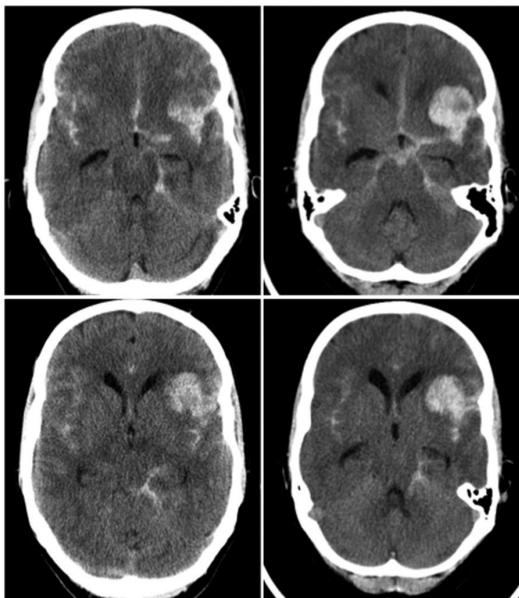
A 41-year-old woman with mild sensory dysphasia presented to a general hospital. Non-contrast CT showed an SAH and a left frontal ICH adjacent to the sylvian fissure (left). Her clinical condition was unchanged at the time of the CT and CTA performed at our institution. CT showed expansion of the left frontal haematoma (right) and a left middle cerebral artery aneurysm that was later coiled successfully.
